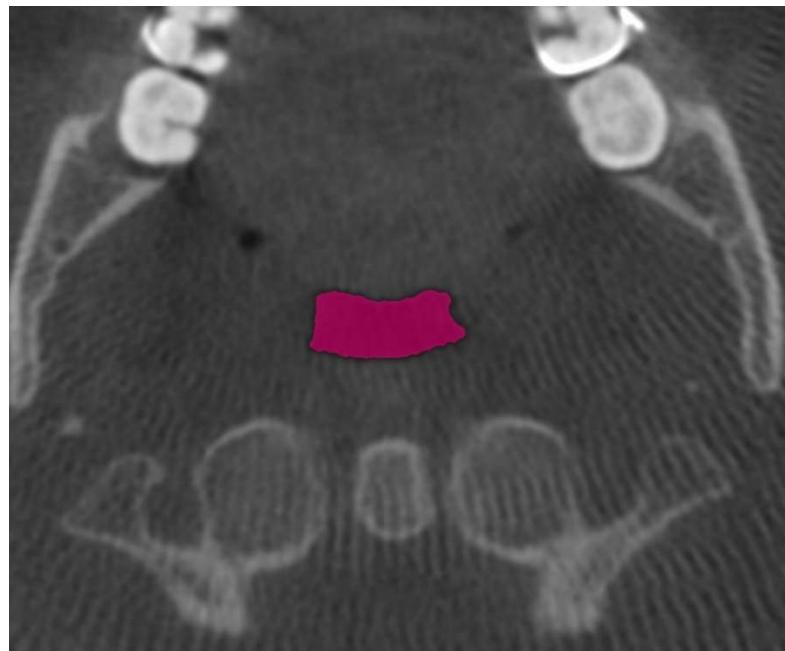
Axial reconstruction of CBCT indicating the minimum cross-sectional axial area (CSA)
